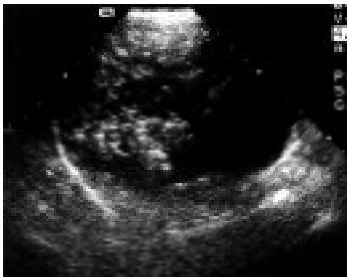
85-year-old woman with HPVG. Liver ultrasonographic scan shows multiple hyperchoic foci scattered within the portal veins. These foci extend to a subcapsular location.
